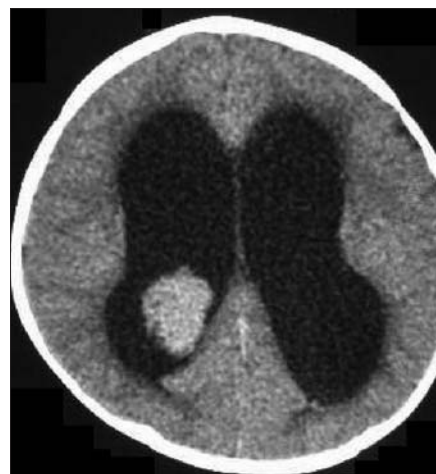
Axial computed tomography scan of the patient showing the tumor in the trigone of the right lateral ventricle
